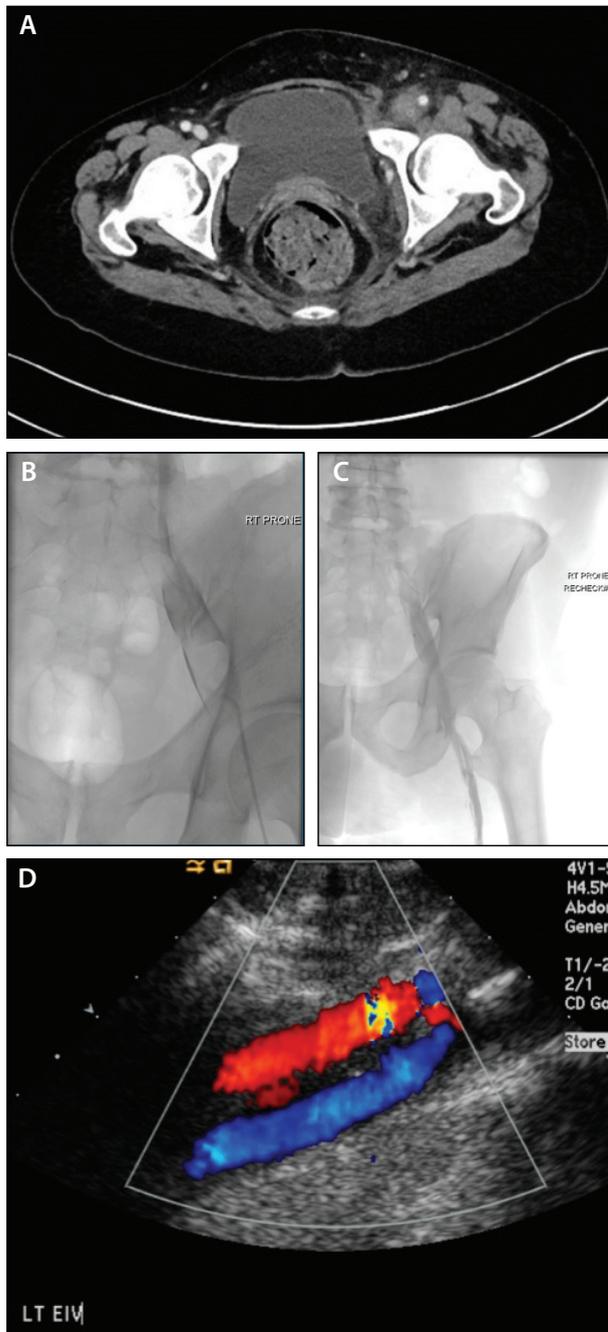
A 50-year-old man with sudden increased right-sided leg swelling after air travel. Ultrasound confirmed lack of flow in the external iliac vein confirming iliofemoral DVT (A), with injection venogram demonstrating significant clot burden in the right common iliac vein (B). TPA infusion initiated via infusion catheter (0.75 mg TPA/hour) with 24-hour recheck demonstrating patency with no stenosis (C). Follow-up ultrasound at 6 months (D) with novel oral anticoagulant demonstrated patency but required use of a class II compression stocking for symptomatic relief of mild post-thrombotic syndrome.
